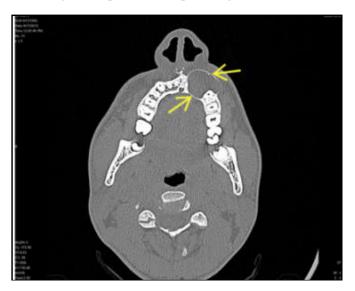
Preoperative CT Scan (axial section) of case 2 showing expansion of the cortex
